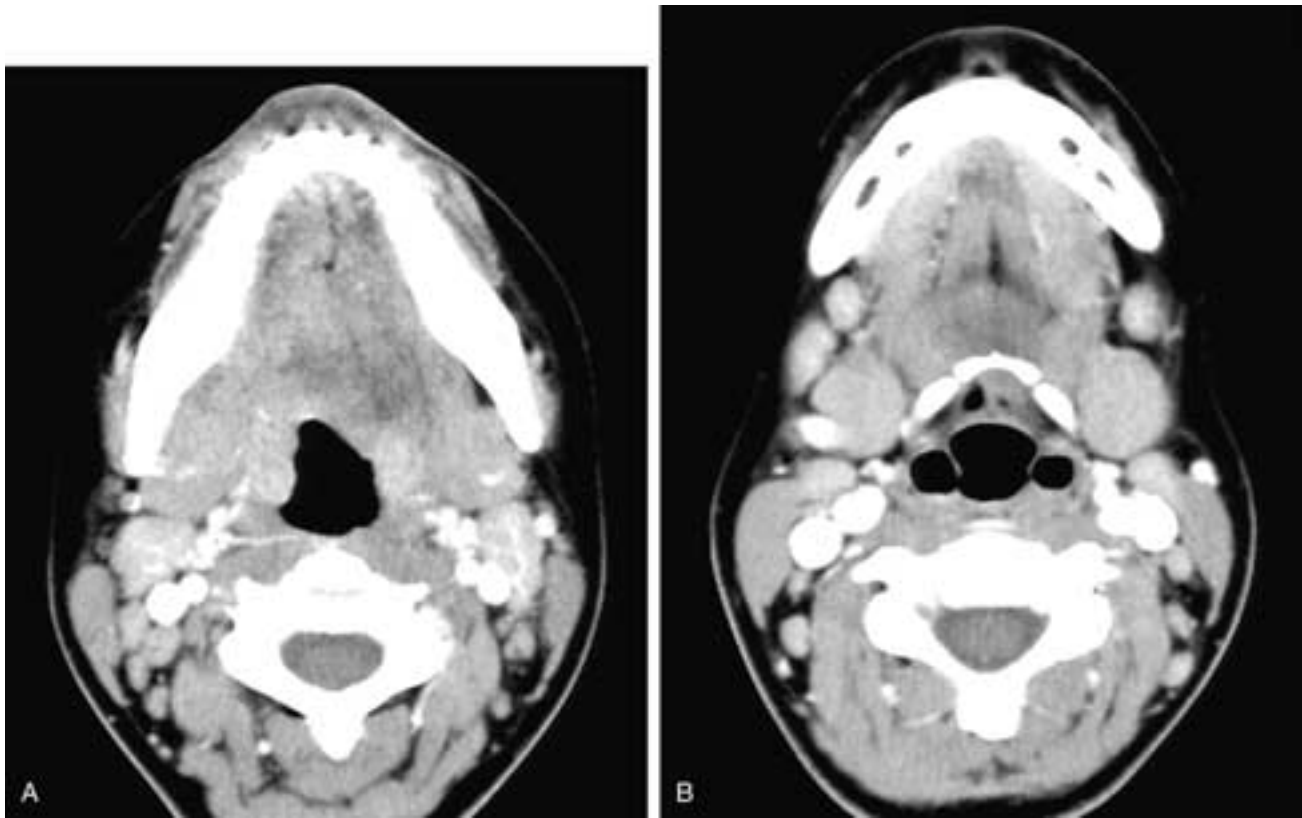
Axial CT scans from cranial (A) to caudal (B) show bilateral level I and level II lymph nodes that do not exceed the size criterion to suspect pathologic adenopathy. The nodes are sharply delineated, and there is some enhancement. These were reactive lymph nodes in this 22-year-old female who had a pharyngitis. Note the slight prominence of the right palatine tonsil.
